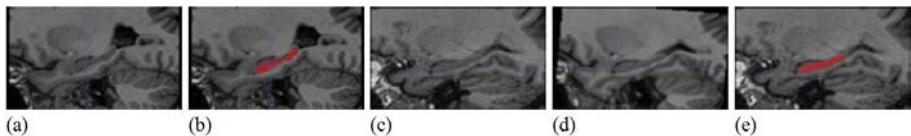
Example of atlas based segmentation of the hippocampus in brain MRI. (a) An MR image used as the atlas. (b) Manual segmentation of the hippocampus in the atlas. (c) The target image in which we want to segment the hippocampus. (d) Atlas warped to the target image using deformable registration. (e) The atlas based segmentation of the target image, overlaid on the target image.
